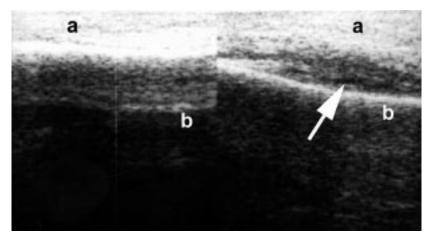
Ultrasonography of the distal pretibial region: the normal right leg (left) and echo-poor areas (arrow) in the left leg (right). a = position of the transducer at the skin surface; b = bone of the tibia.
